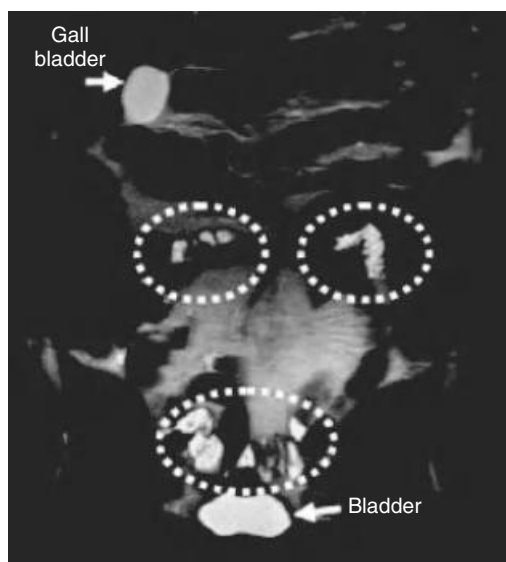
Magnetic resonance images showing the identification and segmentation of intestinal fluid pockets in the fasted state. *Source:* Adapted from Reference 76 with permission.
